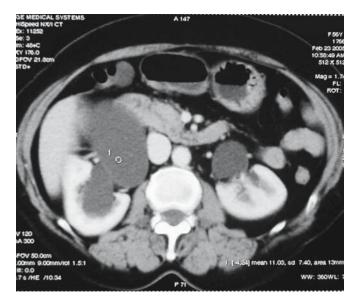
A CT scan reveals a malrotated right kidney with pyelocaliectasis and a doubtful UPJ narrowing on the left side
